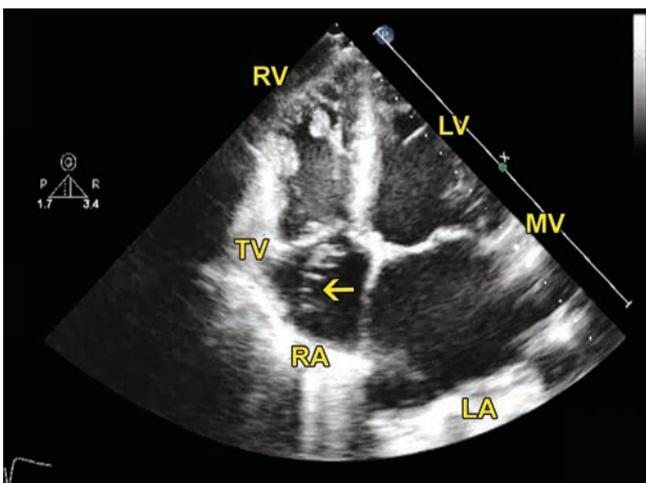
Apical 4 chamber.
